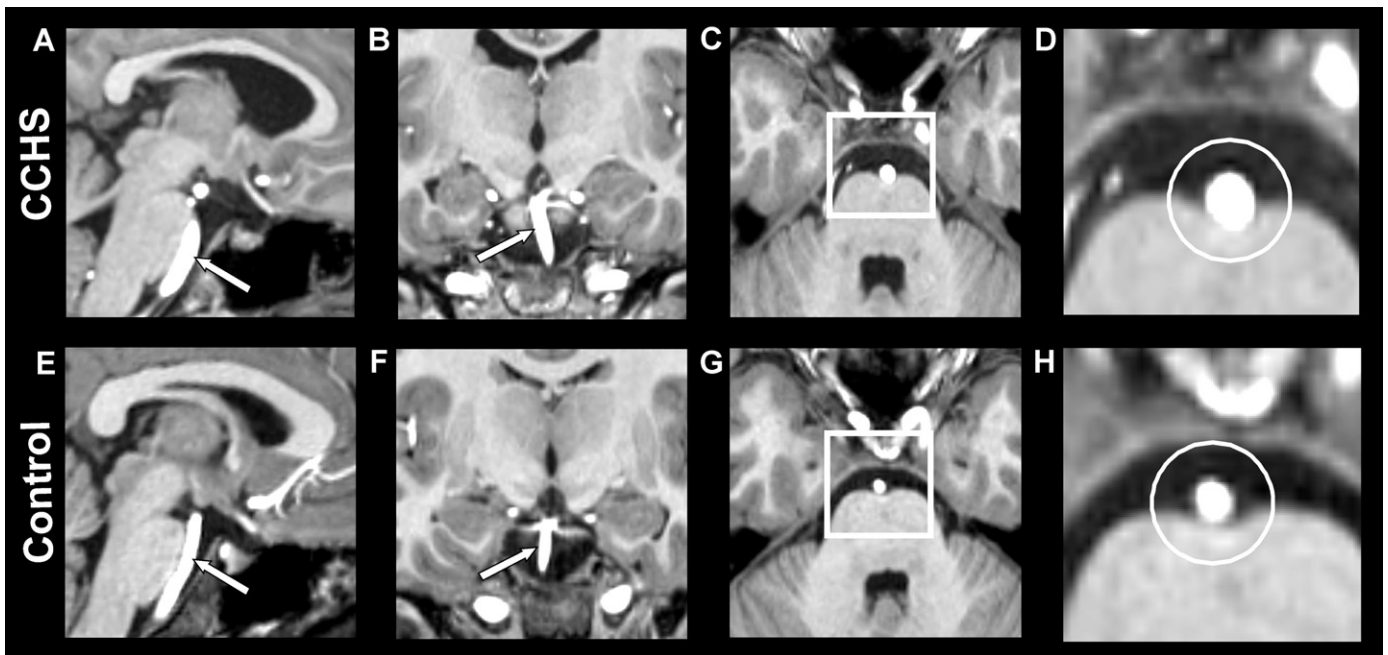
High-resolution T1-weighted images show the basilar artery in a CCHS and control subject. The upper panel shows longitudinal (A, sagittal section; B, coronal section) and cross-sectional views (C, axial section, white square; D, magnified area of the square in image C, white circle) of the basilar artery in a CCHS subject (age 14.3 years, male). The lower panel shows longitudinal (E, sagittal section; F, coronal section) and cross-sectional views (G, axial section, white square; H, magnified area of the square in image G, white circle) of the basilar artery in a control subject (14.4 years, male). The basilar artery cross-section in CCHS is larger than the control subject (D vs. H).
